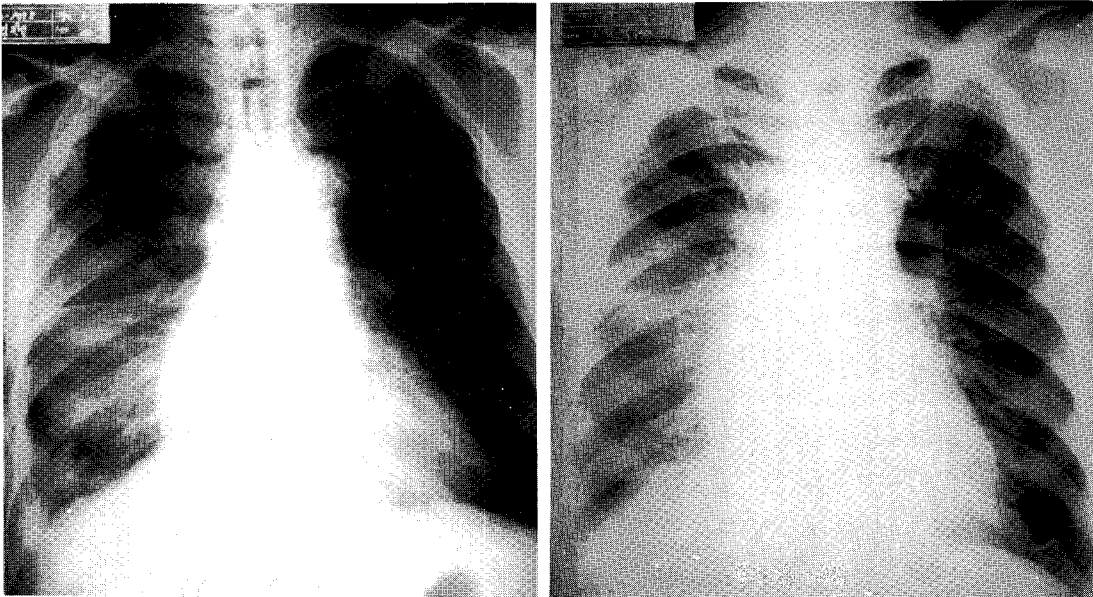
Photographs of X-ray films of the chest taken on admission (left) which showed an increase in haziness of right lower lung and just before discharge (right) revealed the improvement of the lesion.
